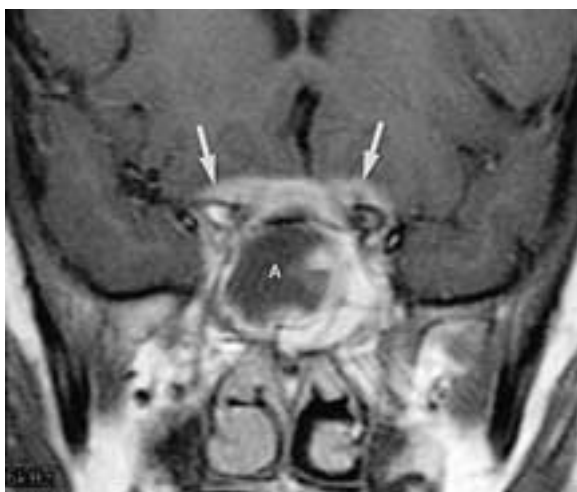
Sphenoid sinus abscess and subperiosteal abscess. Enhanced coronal T1-weighted MR image in a 12-year-old girl showing a sphenoid abscess (A) and a subperiosteal abscess (arrows). The patient lost her vision completely on the right. (From Eustis HS et al. MR imaging and CT of orbital infections and complications in acute rhinosinusitis. *Radiol Clin North Am* 1998;36:1165–1183.)
